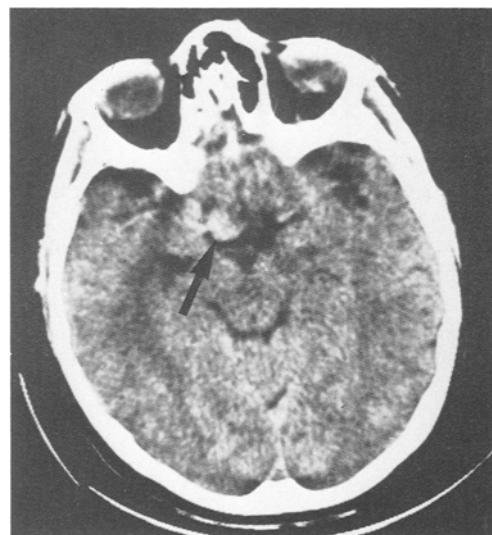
Case 1: Enhanced CT scan showing a right supero-lateral sellar hyperdensity (black arrow) within the optico-chiasmatic cistern consistent with an aneurysm but proved otherwise after angiography
